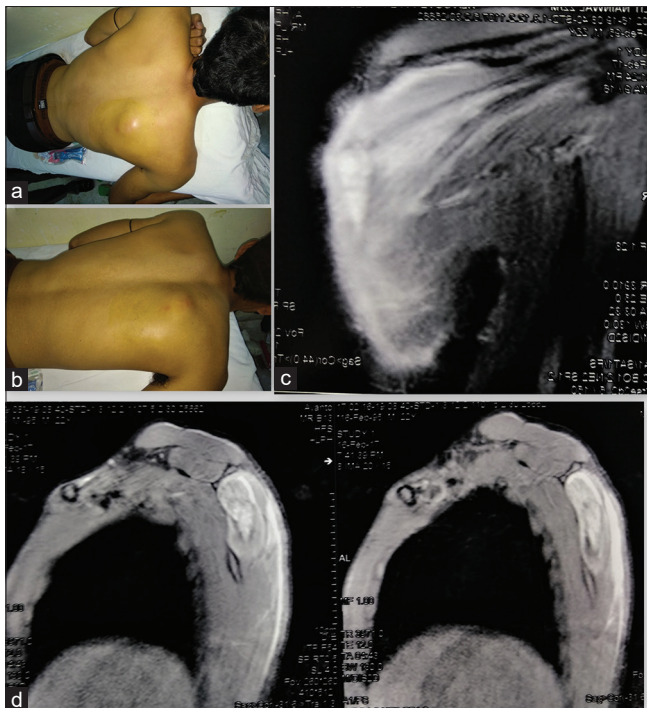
The clinical image showing a tense swelling over the left scapular region (a) painted before the aspiration (b) The MRI images showing infraspinatus muscle edema along its muscle fibres and collection over medial scapular border (c) An encapsulated and localised collection within the infraspinatus muscle can be appreciated in sagittal views (d)
